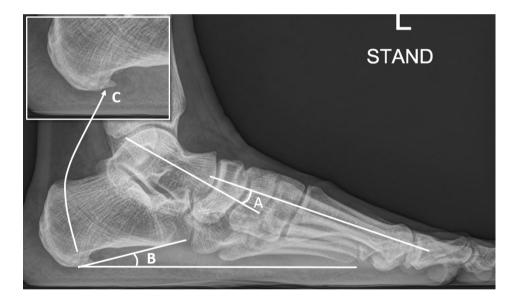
Values measured from a standing lateral radiograph of the foot. (A) lateral talar-first metatarsal angle (a positive value indicates convex upward), (B) calcaneal pitch angle, which is the angle between a line tangent to the plantar border of the calcaneus and a line from the plantar-most point of the calcaneal pitch metatarsal, (C) calcaneal
